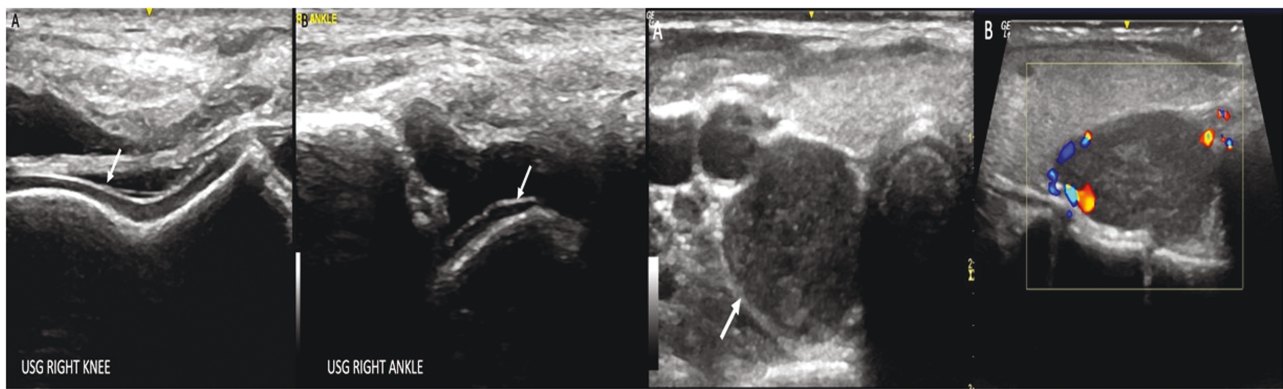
(Left): Ultrasound images of joints. A, Knee joint. B, Ankle joint: Arrows show the hyperechoic band at the cartilage-synovial interface due to monosodium urate crystal deposition on the cartilage surface. Knee and ankle joint effusion is also evident. (Right). Ultrasound imaging of the neck. A, Transverse image showing a well-circumscribed hypoechoic solid mass lesion (arrow) posterior to the right lobe of the thyroid. B, Color Doppler image, longitudinal view shows peripheral vascularity in the solid nodule.
